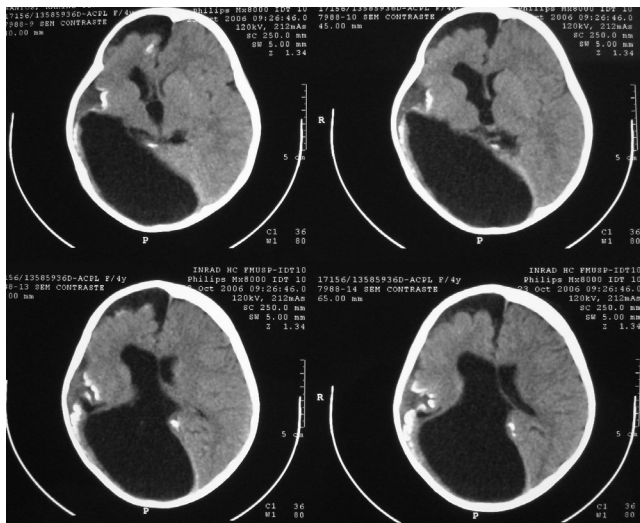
CT scan of the brain shows: pencephalic cyst, hemiatrophy of the right hemisphere, subdural collection and parietal calcifications
